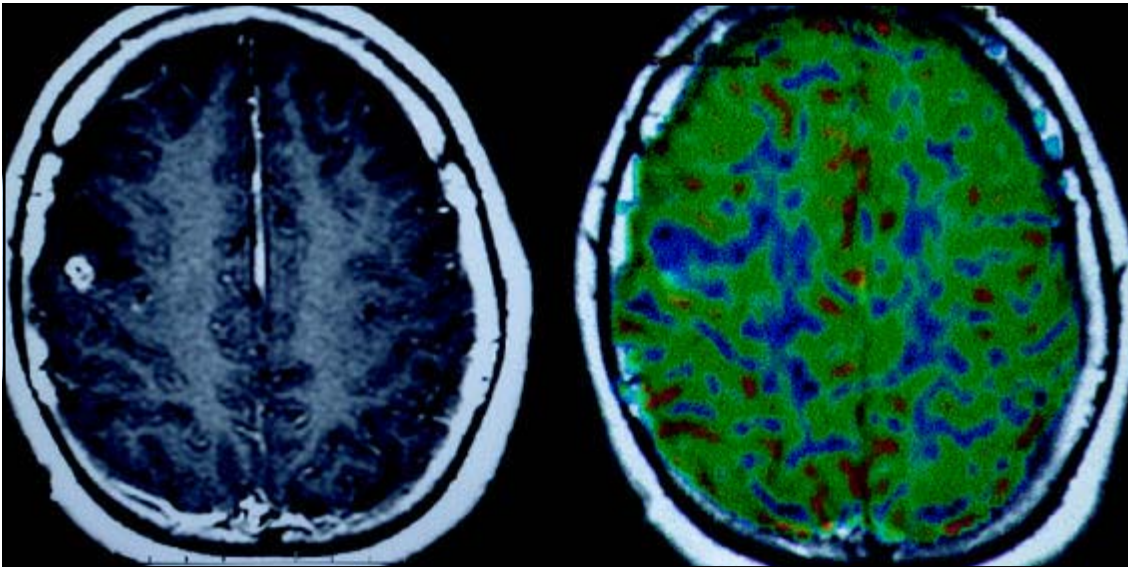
MRI T1WI postcontrast (Gd-DTPA) - ring enhanced lesion in the frontal lobe. MR PWI - without high perfusion. Follow-up confirmed cysticercosis.
